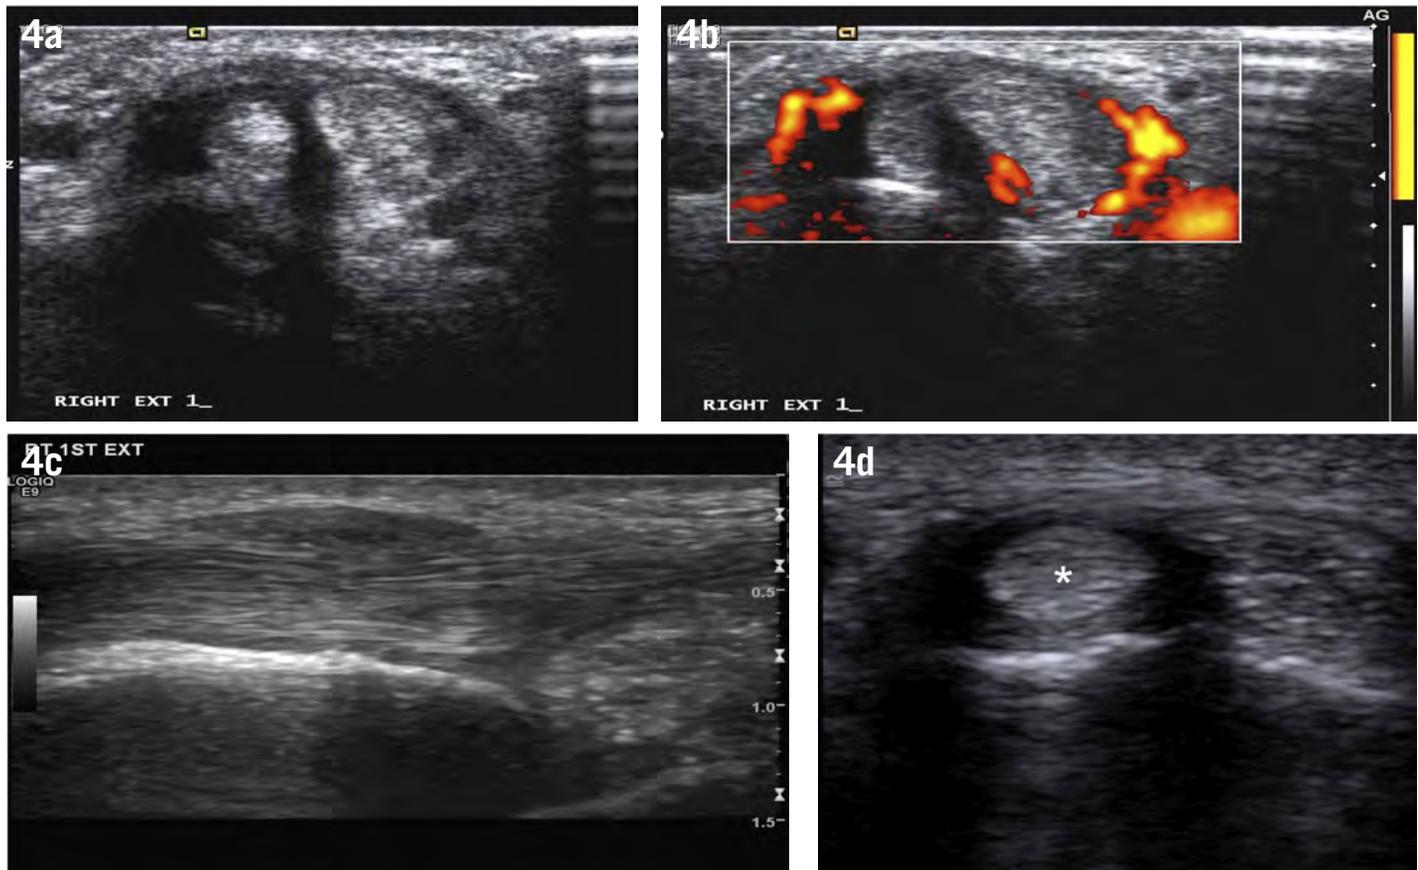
(a) Transverse ultrasound image demonstrating the typical grayscale ultrasound findings of hypoechoic thickening of the tendon sheaths of extensor compartment 1, predominantly involving the extensor pollicis brevis. This thickened tissue demonstrates vascularity on power doppler (b). (c) shows longitudinal scan of a different patient showing thickening of the extensor compartment 1 retinaculum resulting in stenosis of the compartment. (d) The ultrasound scan shows typical appearances of a double tunnel extensor compartment 1 with a ridge demonstrated in the underlying radius and persisting tenosynovitis in the extensor pollicis brevis portion of the compartment.
